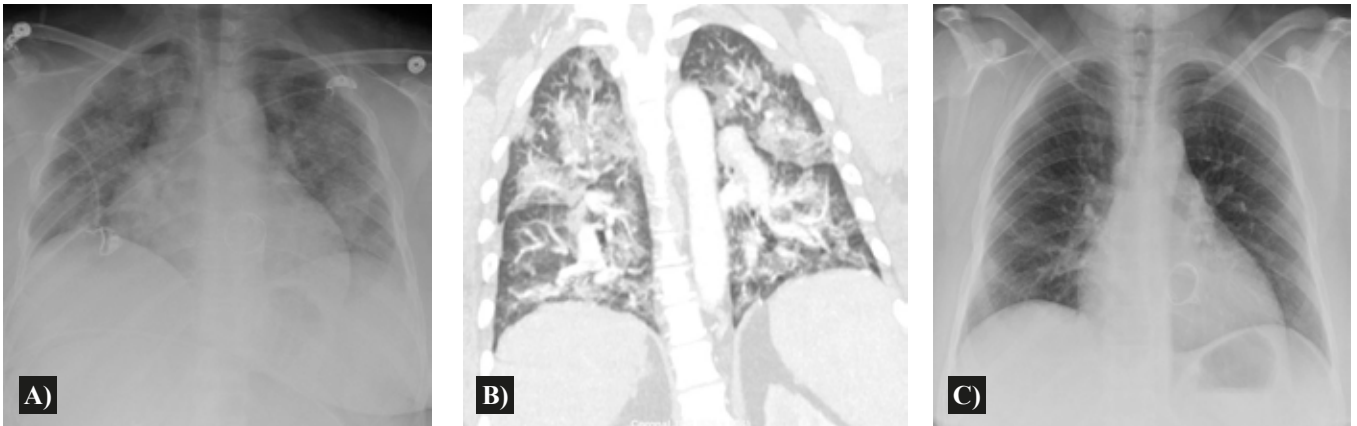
CXR completed at time of presentation reveals bilateral airspace disease (a). Coronal CT chest images completed at the same time reveal bilateral, predominantly central, heterogeneous groundglass opacities, involving both upper and lower zones with subpleural sparing (b). These opacities quickly resolved upon treatment with high-dose corticosteroids and IV cyclophosphamide (c).
